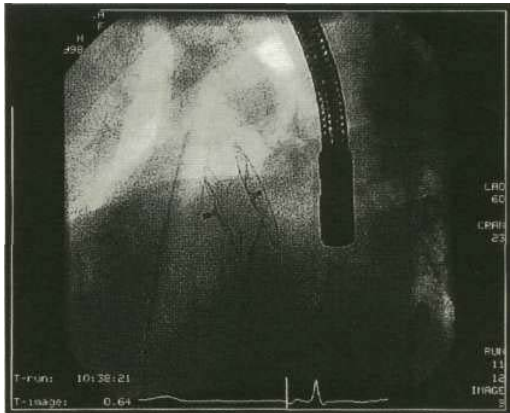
The angiographic appearance of a fully deployed ASD closure device. The device bridges the ASD and wedges against the surfaces of the right and left atrial septa, occluding flow. The metal object in frame is the distal end of a transoesophageal echocardiography probe. Courtesy of Dr D Ward.
